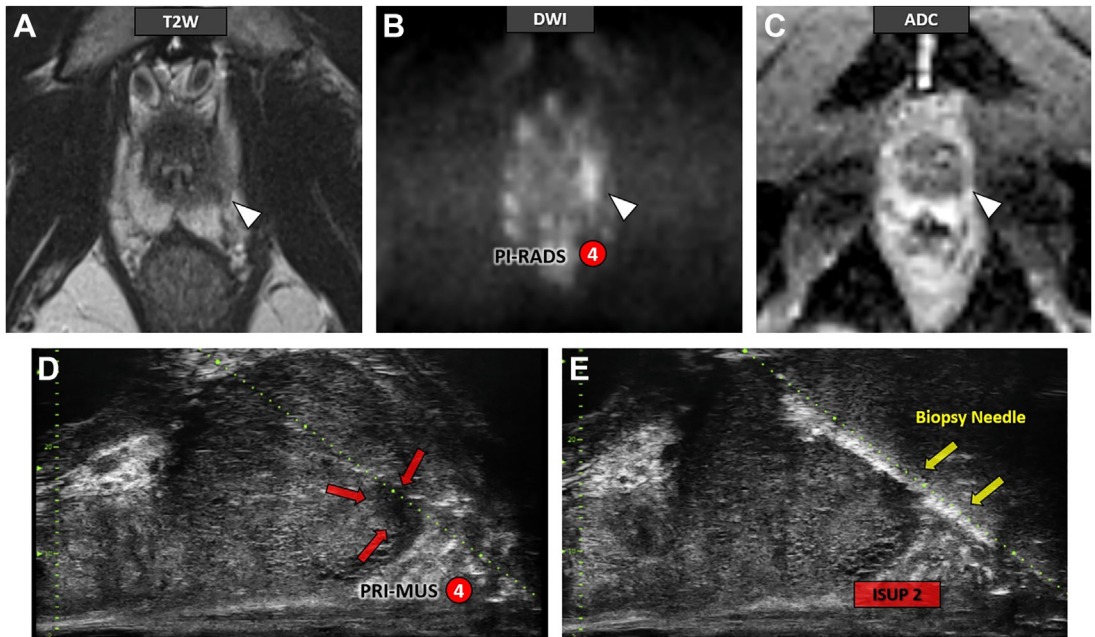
Images in a 60-year-old man with prostate-specific antigen level of 4.5 ng/mL. Multiparametric MRI scans (axial T2-weighted image [A], diffusion-weighted image [B and ADC map [C]) show a PI-RADS 4 lesion in the left apex peripheral zone (*arrowheads*). MicroUS scan (D) shows the corresponding index lesion with smudgy pattern (PRI-MUS 4) (red *arrows*). Targeted biopsy revealed grade group 2 disease (E). PI-RADS, Prostate Imaging Reporting and Data System; PRI-MUS, Prostate Risk Identification Using Micro-Ultrasound.
